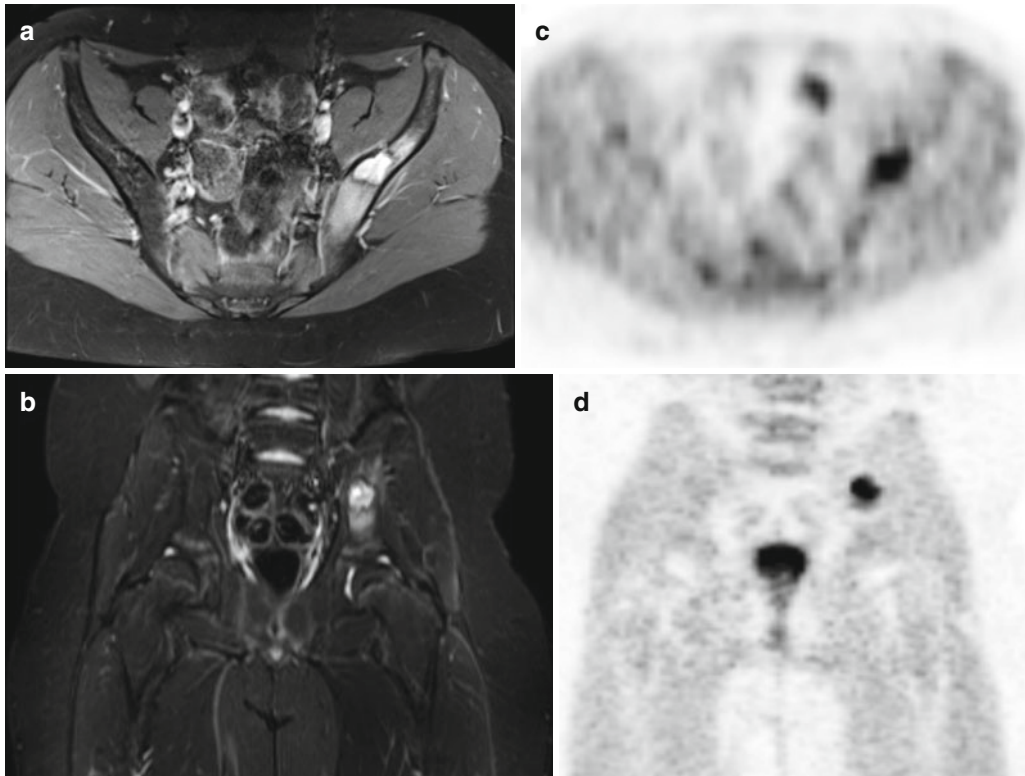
Simultaneous MRI/PET acquisition of the pelvis in an 11-year-old boy with pain in the left hip. A contrast-enhancing lesion with surrounding bone marrow edema is seen on axial T1-weighted fat-saturated (a) and coronal T2-weighted (b) MRI images in the left iliac crest.
